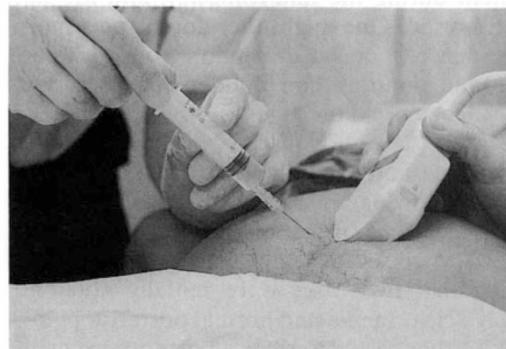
Amniocentesis performed under real-time ultrasonography.
